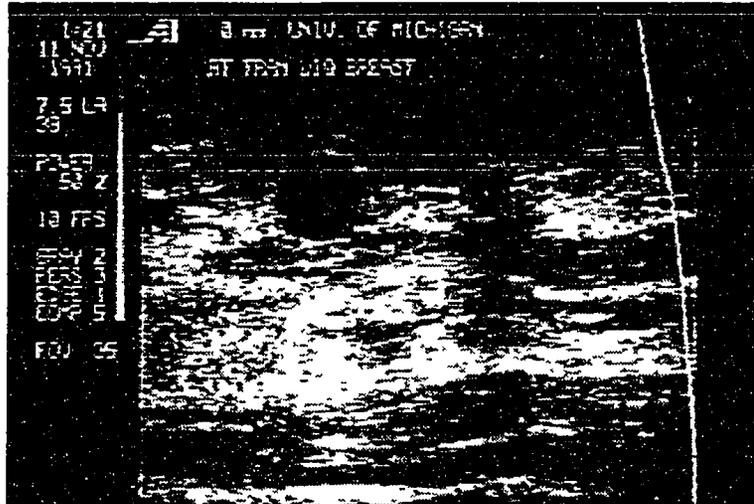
Ultrasound from patient A.
